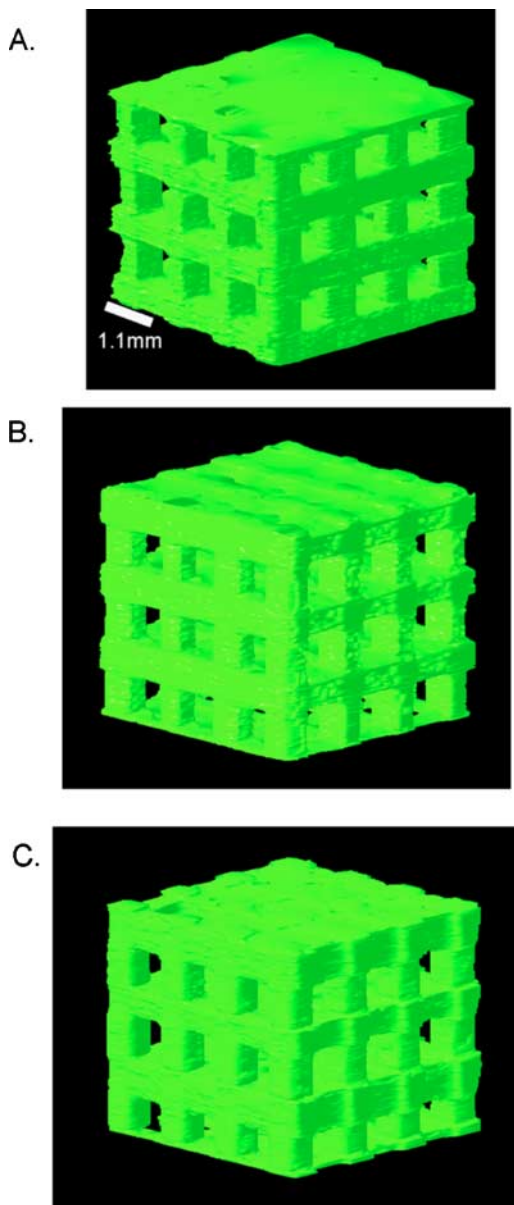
Reconstructions of X-ray CT images from selected parts. Subsections are presented for visual clarity. Part #2 (A), Part #4 (B), Part #17 (C).
